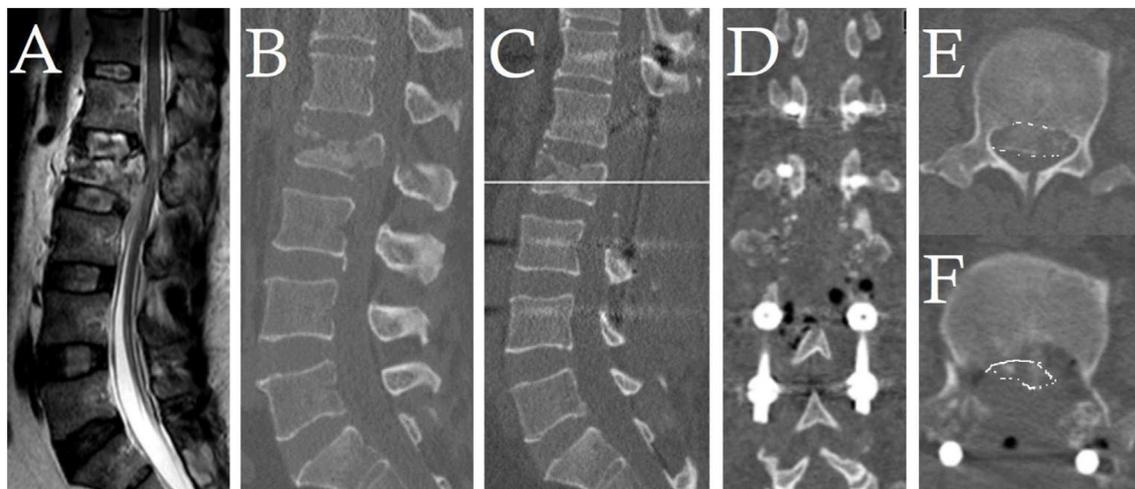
Pre and postoperative imaging of patient n.15: (A) preoperative sagittal MRI T2 showing L2 severe burst fracture with conus compression and cord signal; (B) preoperative sagittal CT scan showing canal compression at L2; (C) postoperative sagittal CT scan showing the decompression of burst fracture and laminectomy and shadows of screws two levels above and below fracture level; (D) postoperative coronal CT scan showing the drilled pedicles bilaterally and the eight screws; (E) preoperative axial CT scan showing about 60% canal compromise (retropulsed bone fragment encircled by dotted line); (F) postoperative axial CT scan showing the bilateral transpedicular approach and decompression of the canal (20% canal compromise, residual bone fragment encircled by dotted line).
